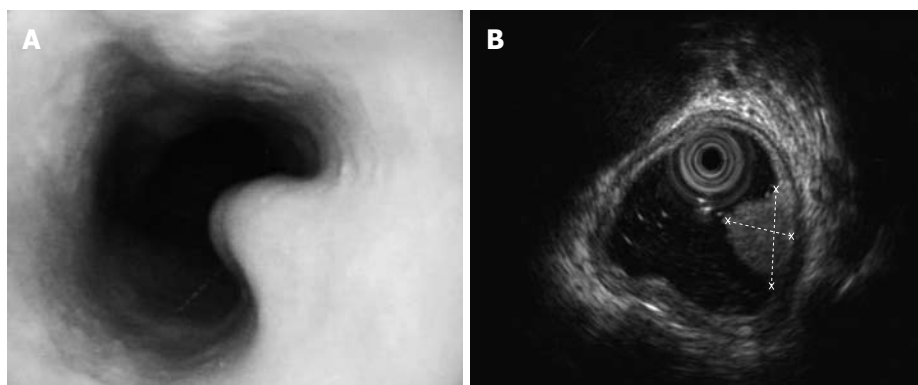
Soft yellow nodules protruding into the esophageal cavity. A: Gastroscopy presentation: soft yellow nodules protruding into the esophageal cavity; B: Endoscopic ultrasonography: a space-occupying lesion (8.1 mm × 5.1 mm) in the substratum sized 8.1 mm × 5.1 mm (dotted lines).
